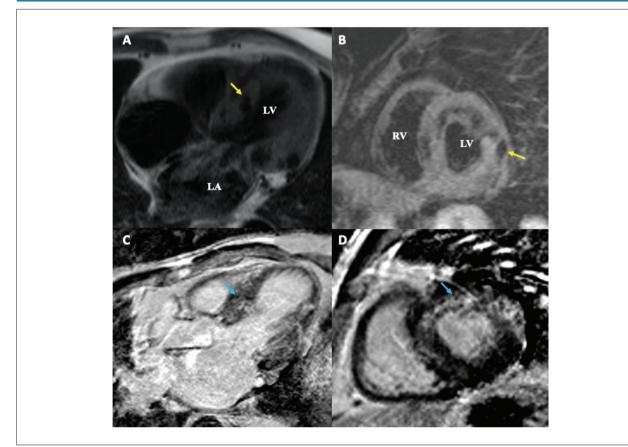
Cardiac Magnetic Resonance Imaging (CMR). T1 weighted sequence show signs of left ventricle hypertrophy with intramyocardial low signals compatible with calcium (A), T2 weighted sequence without edema and intramyocardial low signal (B). Diffuse intramyocardial Late gadolinium enhancement (LGE), without a characteristic pattern (C and D). The yellow markers show myocardial calcium distribution. The blue markers show myocardial LGE. LV: left ventricle; RV: right ventricle; LA: left atrium.
